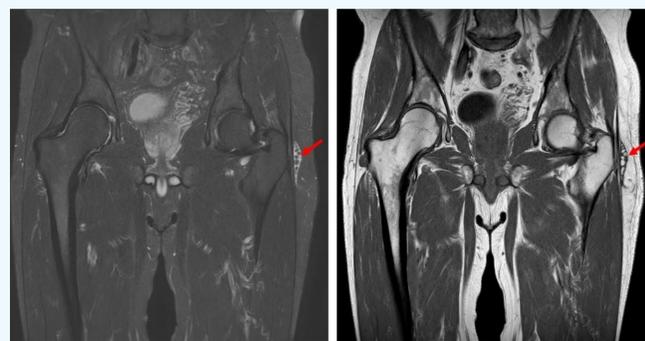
Coronal T1 (A) and T2 fat-saturated (B) MRI images showing Morel-Lavallée lesion around the greater trochanter
